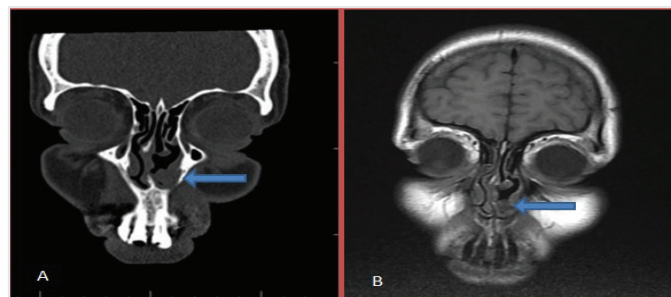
Coronal computed tomography (A) and T1-weighted magnetic resonance (B) images
